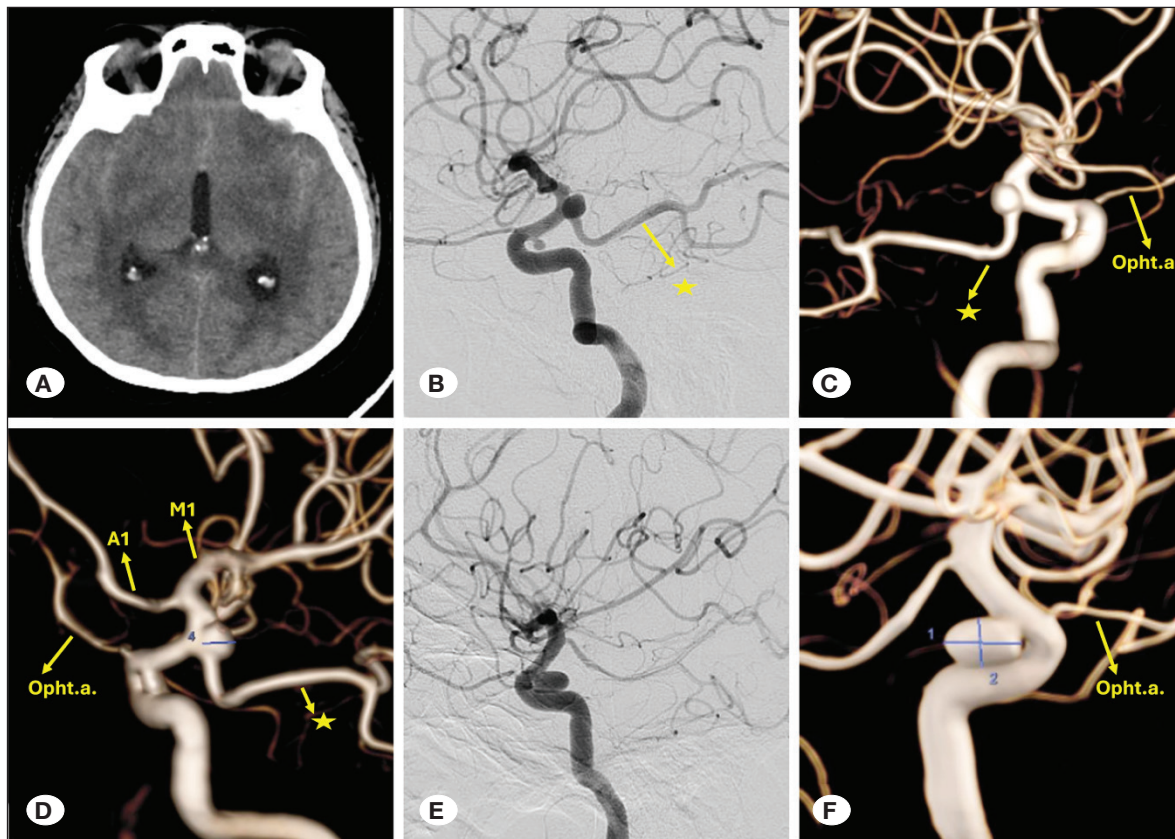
Pre-treatment imaging in a patient with bilateral ICA aneurysms. A) Axial cranial CT scan showing subarachnoid hemorrhage in the bilateral Sylvian cisterns. B) Lateral view DSA image following right ICA injection, demonstrating two saccular, wide-necked aneurysms: an inferiorly projecting aneurysm at the right ICA paraophthalmic segment measuring 2.8×2.4 mm, and an aneurysm originating from the right ICA Pcom segment measuring 6.6×4.4 mm. (yellow star: fetal Pcom). C) 3D reconstructed DSA image (oblique view) and D) posterior-anterior view of the same right ICA aneurysms. E, F) Lateral view and 3D reconstructed DSA image following left ICA injection, showing a saccular, wide-necked aneurysm at the left ICA paraophthalmic segment measuring 7.6×4.8 mm.
